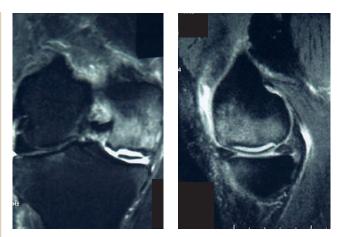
Case 2—22 days after surgery, fat-suppressed T_2 -weighted coronal (A) and sagittal (B) magnetic resonance images show a frank osteochondral fracture of the medial femoral condyle and associated avascular necrosis of a large, detached, nondisplaced osteochondral fragment.
